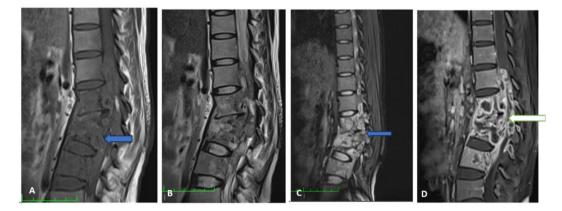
Pyogenic spondylitis in a 20 year old girl. (A) T1-weighted sagittal image (B) T2-weighted sagittal image (C) Sagittal STIR image show L1 vertebral and D12-L1 intervertebral disc destruction with heterogeneous abnormal signal intensity from D12-L2 vertebrae; also note epidural extension and subligamentous spreading from D11 – L2 level (blue arrow).(D) Fat-sup-pressed CE T1-weighted sagittal image shows multiple thick, irregular wall intraosseous abscesses with epidural and subligamentous spread along posterior longitudinal ligament from D11-L2 level (white arrow).
